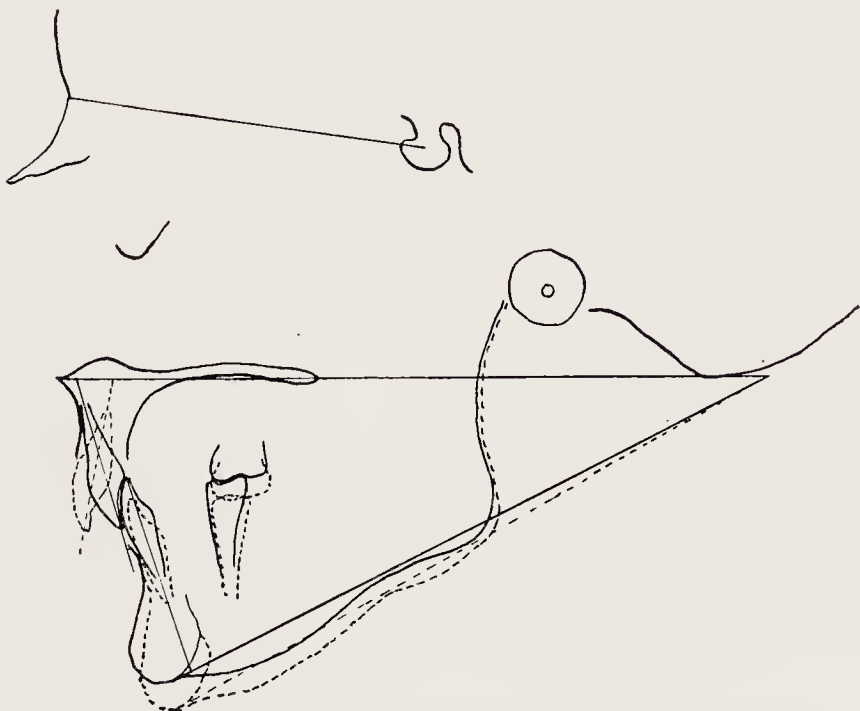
Case 1. Tracings of lateral skull radiographs, superimposed on S-N plane, of a patient who has worn an anterior bite-plate for two years.
